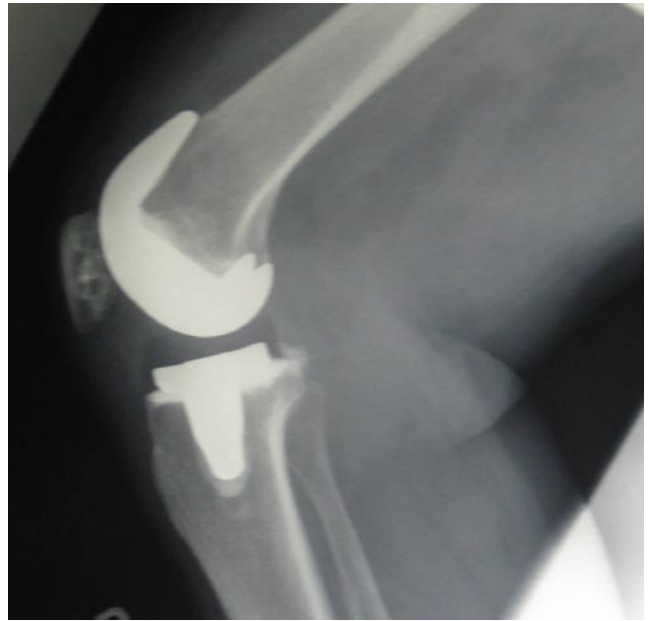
Postoperative lateral radiograph showing right total knee arthroplasty.
